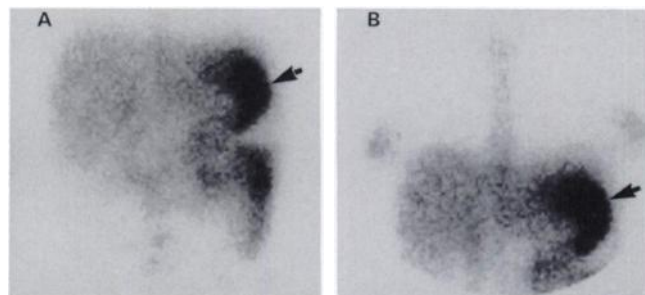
(A) Planar anterior ^{67}Ga scintigram of the abdomen shows stomach (arrow) and colon. (B) Planar anterior view of the chest and upper abdomen. Both the fundus and body of the stomach are prominently highlighted (arrow).
